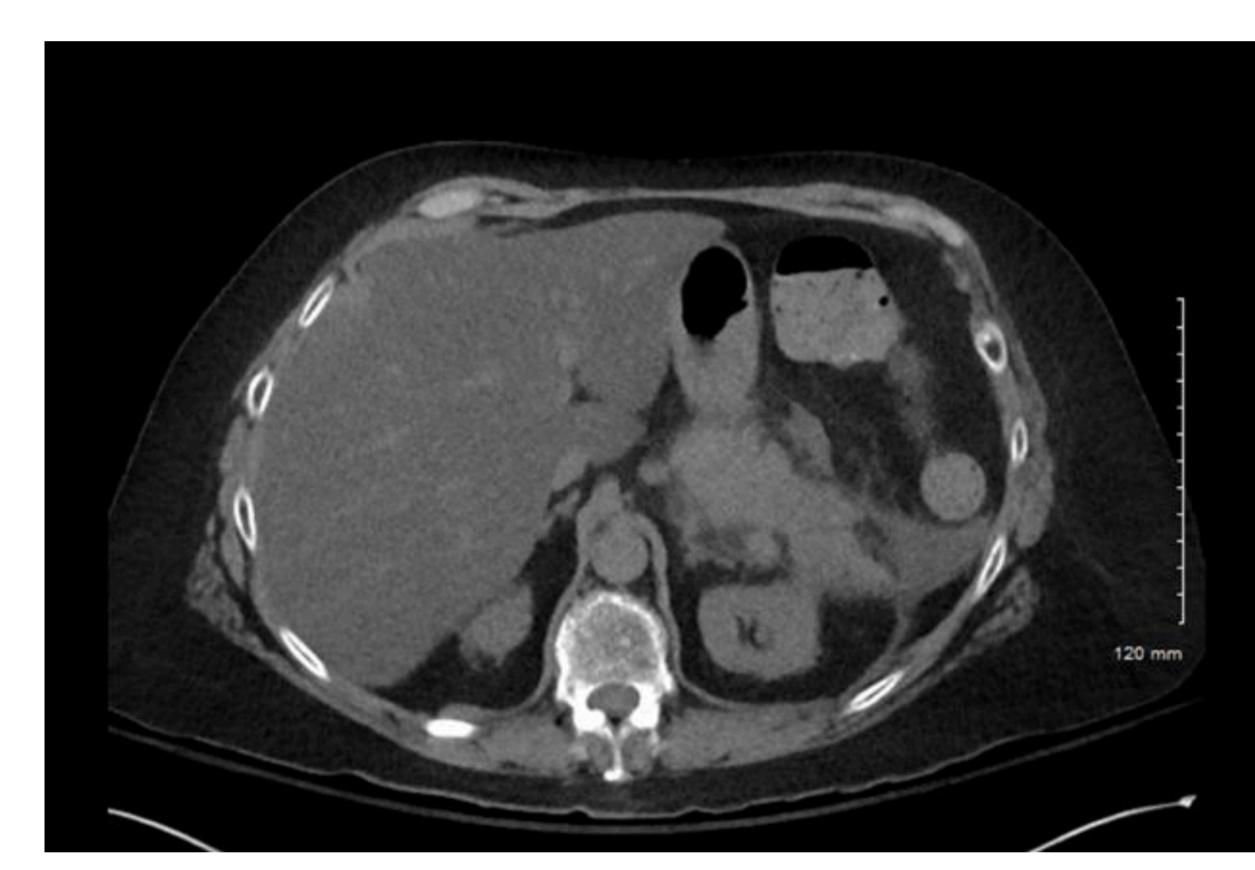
CT A/P. Acute interstitial pancreatitis. No obvious necrosis or peripancreatic fluid.
